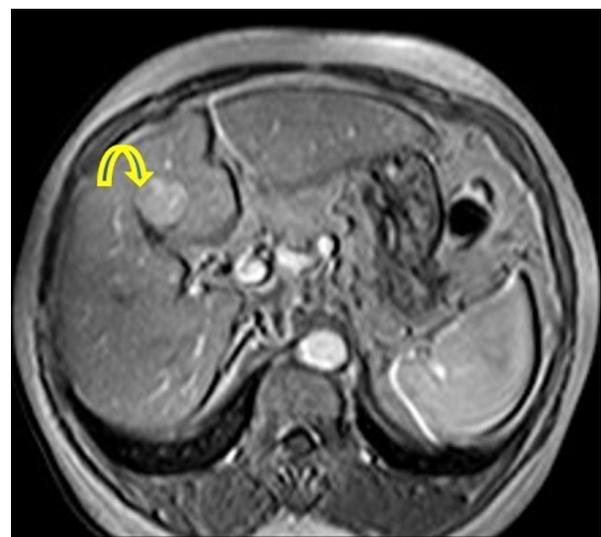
Diffusion-weighted magnetic resonance imaging of hepatitis B positive 50-years-old man. The arrow indicates hyperintensity.
